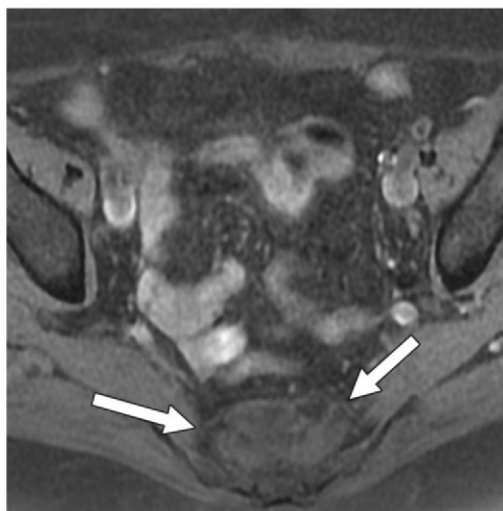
Presacral myelolipoma in a 74-year-old woman. Sagittal T2-weighted MR image (a), axial T1-weighted MR image (b), and axial fat-suppressed T1-weighted MR image (c) show a lobulated presacral mass (arrows). The mass demonstrates heterogeneous predominantly high signal intensity relative to that of muscle in a and b and loss of signal intensity in c.
